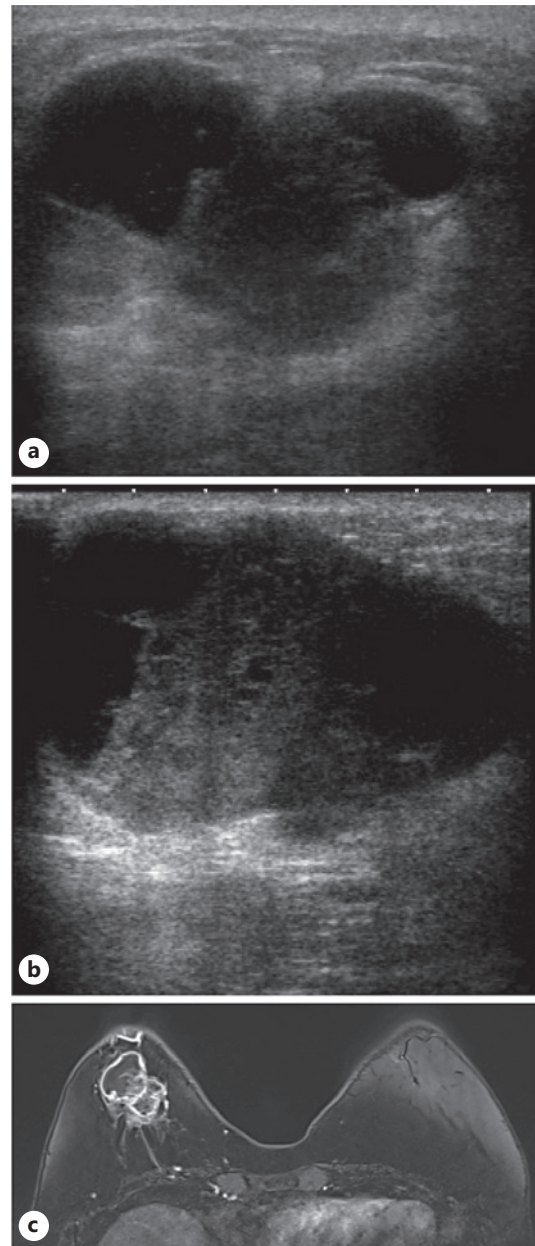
a Ultrasonography after three courses of Tmab+Pmab+DTX showed the tumor growth to 3.3 cm in size. b Ultrasonography after two courses of EC showed that the tumor was enlarged and out of frame. c MRI showed the tumor with internal degeneration suspected of necrosis.
